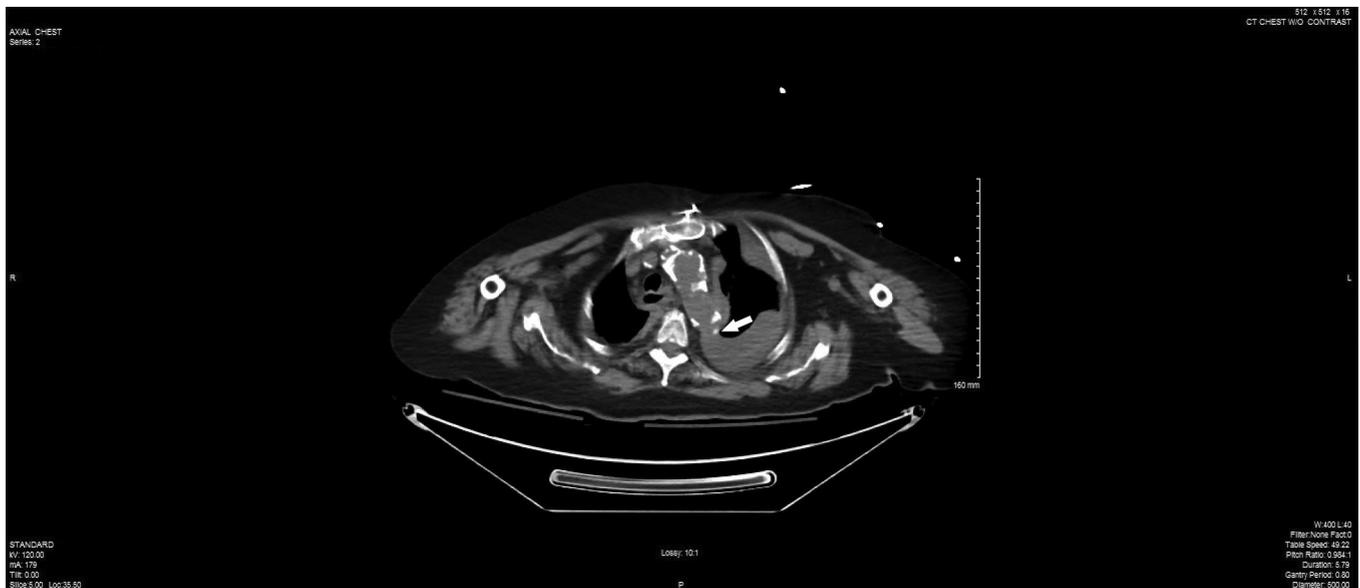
Non-contrast CT scan of chest (proximal window).
